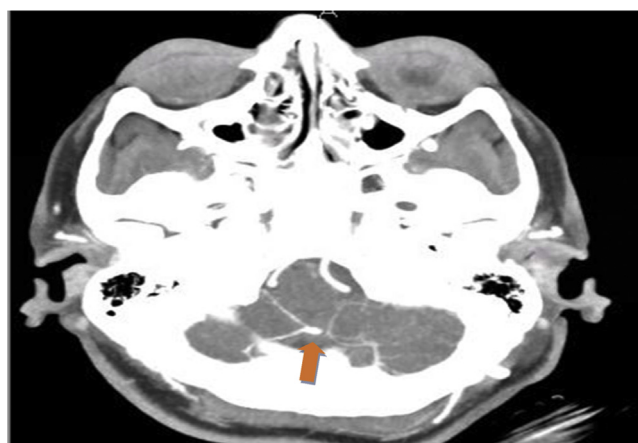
CT scan (axial) showing the aneurysm. It is located almost in the midline. Orange arrow points to the region of the aneurysm.
